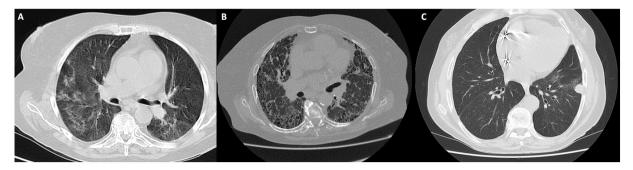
Representative images of HRCT in RA. Different patterns of HRCT lung involvement are recognized in RA patients; A) ground glass opacities, B) interstitial inflammation and honeycombing affecting subpleural areas, C) rheumatoid nodule are shown, respectively.
